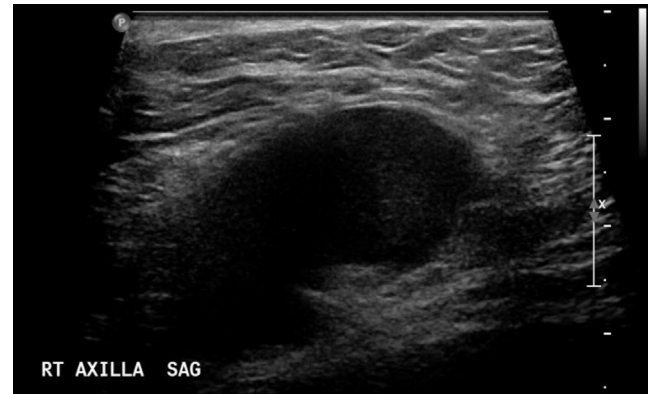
Ultrasound imaging of abnormal lymph node (image courtesy of A. Chau, Department of Breast Imaging; H. Lee, Moffitt Cancer Center and Research Institute).
